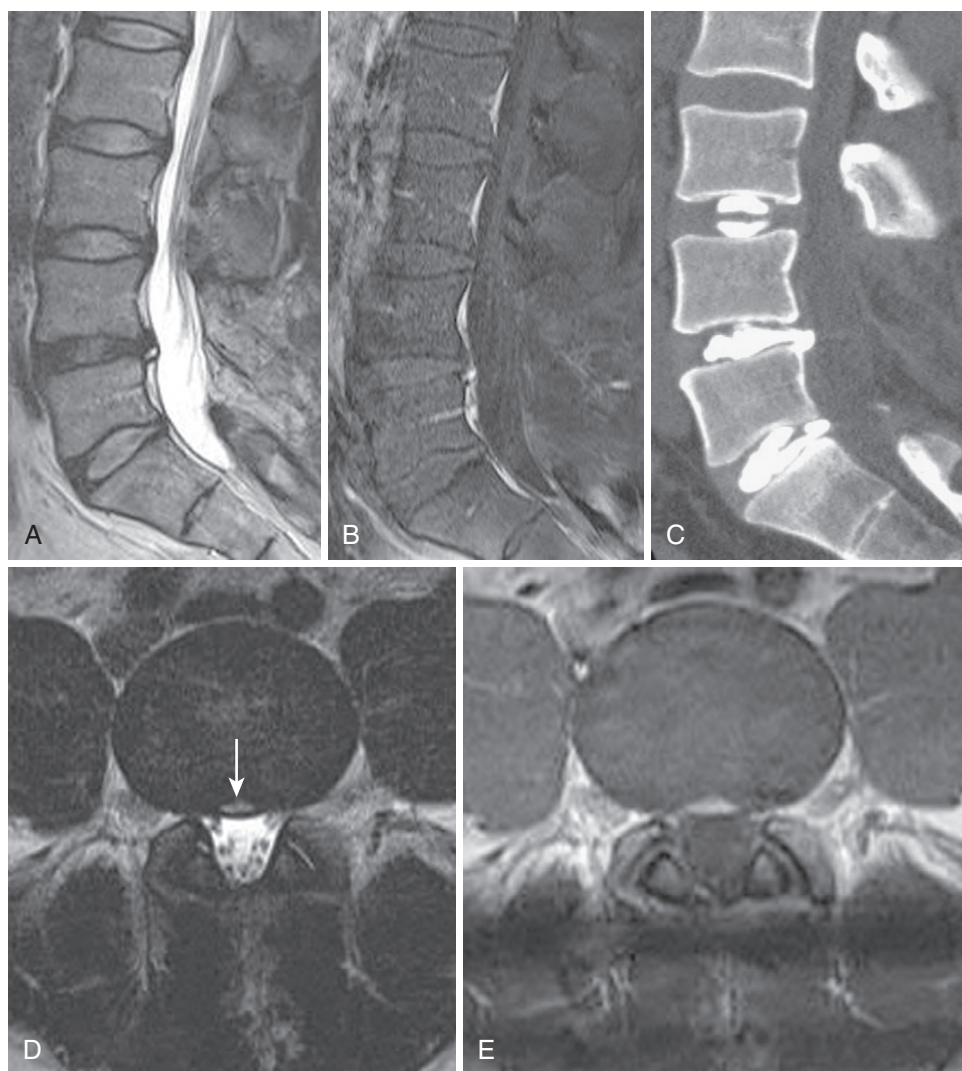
High Intensity Zone (HIZ). Middle-aged male has previously undergone L4-5 decompressive procedure, without diskectomy, for back and leg pain. Axial back pain was unrelieved. A, Sagittal T2-weighted MRI shows loss of T2 signal in the L4 disk with an HIZ in the posterior annulus. D, Axial T2 MRI image at L4-5 interspace demonstrates the HIZ (*arrow*) in the posterior annulus. E, Axial enhanced T1 MRI image showing enhancement in the HIZ, also demonstrated in the sagittal fat-saturated T1 image (B). Sagittal postdiskogram CT (C) demonstrates annular fissure at L4-5 leading to HIZ. Pressurization of the L4-5 disk produced concordant axial pain at < 20 pounds per square inch (PSI) above opening pressure. (From Maus TP, Aprill CN. Lumbar discogenic pain, provocation diskography, and imaging correlates. *Radiol Clin North Am.* 2012;50:681-704.)
